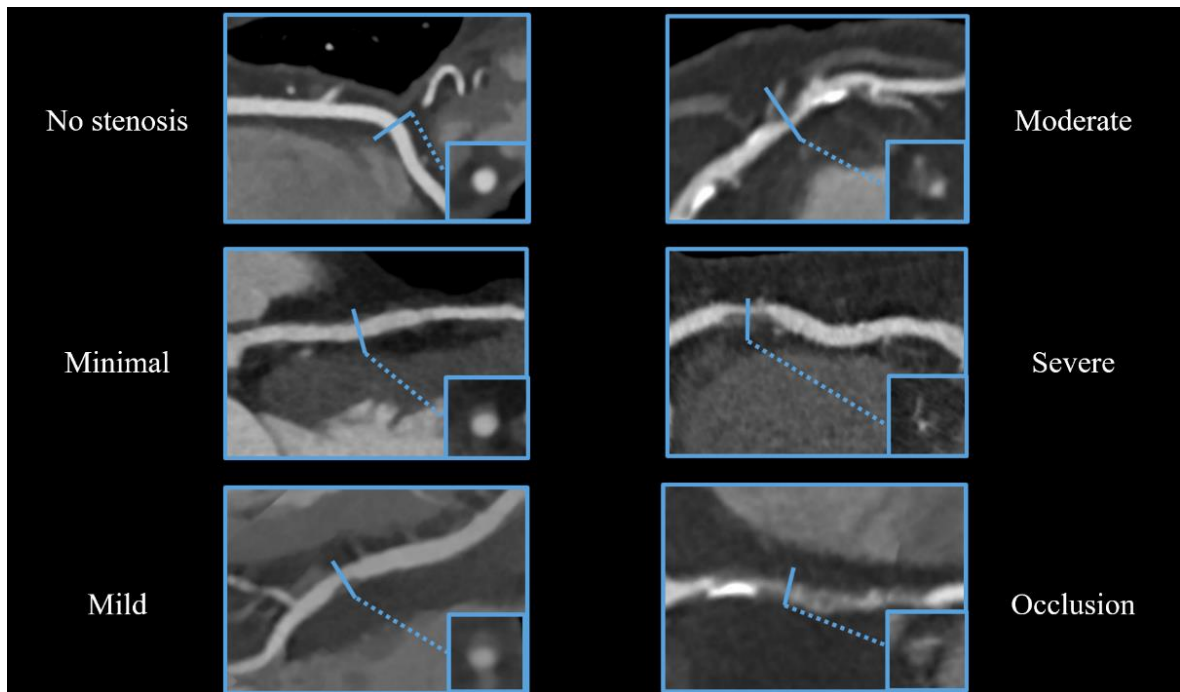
Representative images for stenosis classification using CTA images (*own material*).
